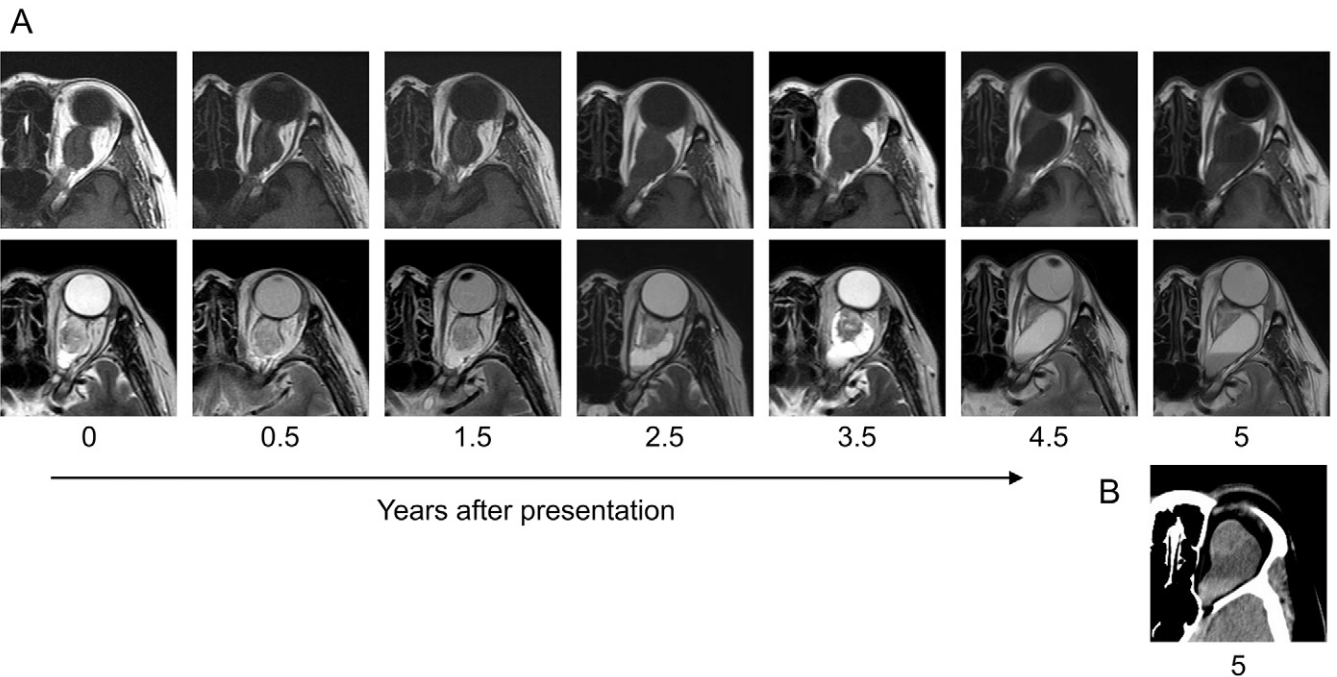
A: Time series of axial T1- and T2-weighted MRI of the left orbit showing slow progression of the tumor with cyst formation. B: Left orbit CT showing intracystic hemorrhage.
